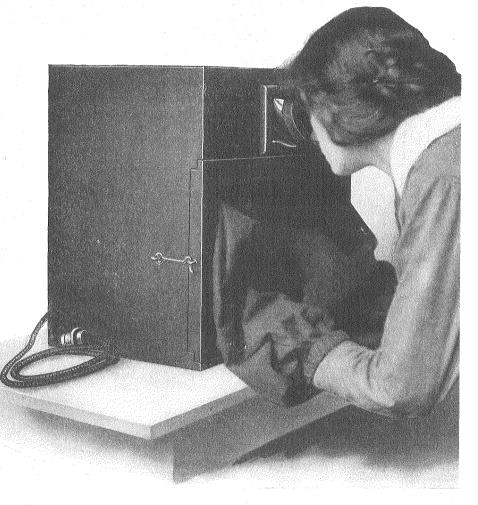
Portable dark-room box for developing films. (Courtesy of American X-ray Equipment Company.)
